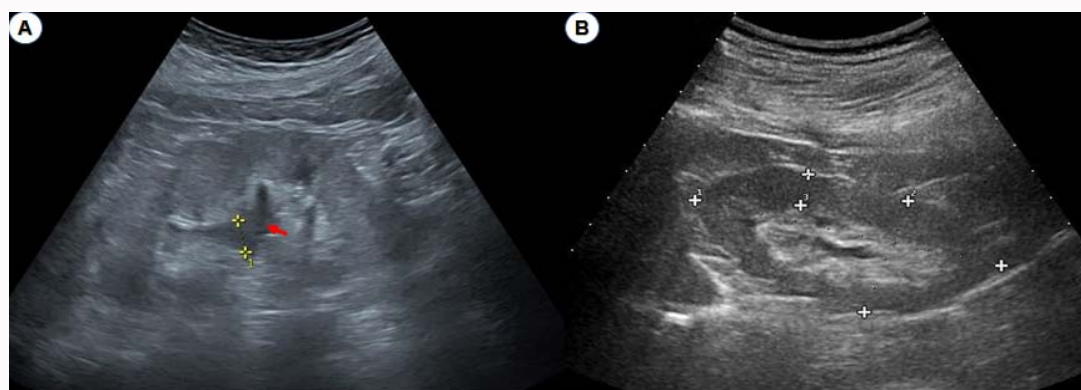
Ultrasonography has an important role in evaluation of hydronephrosis. (A) Hydronephrosis in right kidney before treatment. (B) Hydronephrosis is relieved on the 40th day.
